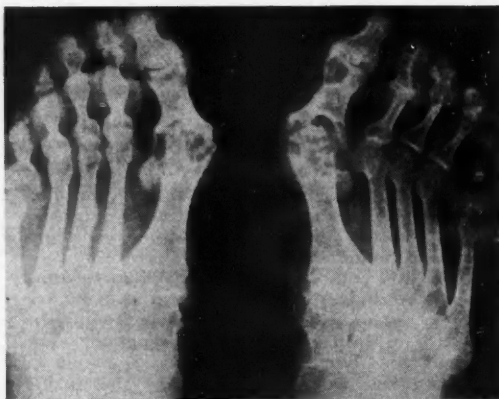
Roentgen changes typical of gout in feet.
